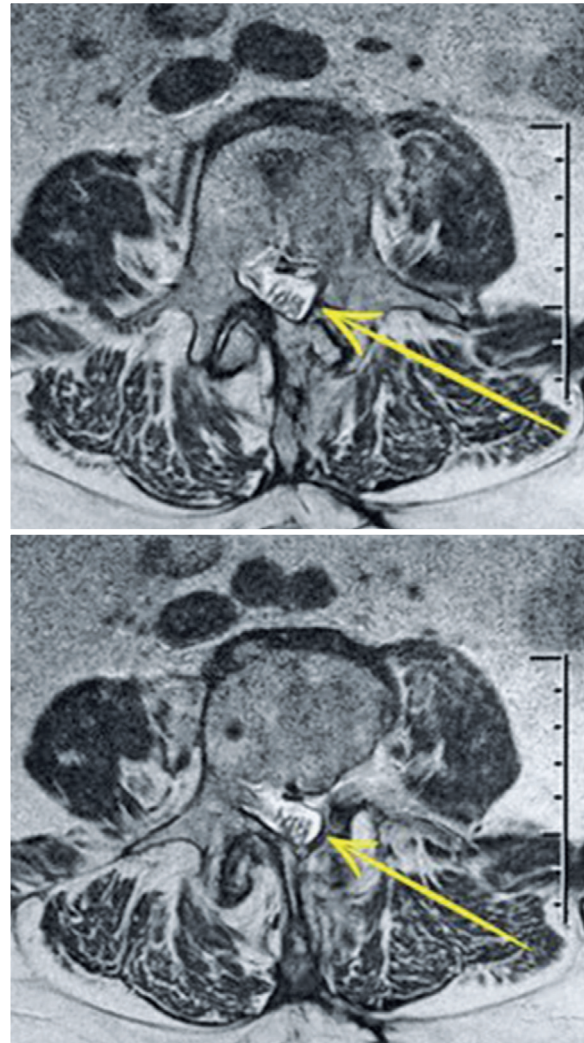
Lumbar spine magnetic resonance imaging (MRI) six months after hemilaminectomy, showing fibrotic-scar tissue changes with edema foci in the paravertebral and spinal erector muscle bellies.
